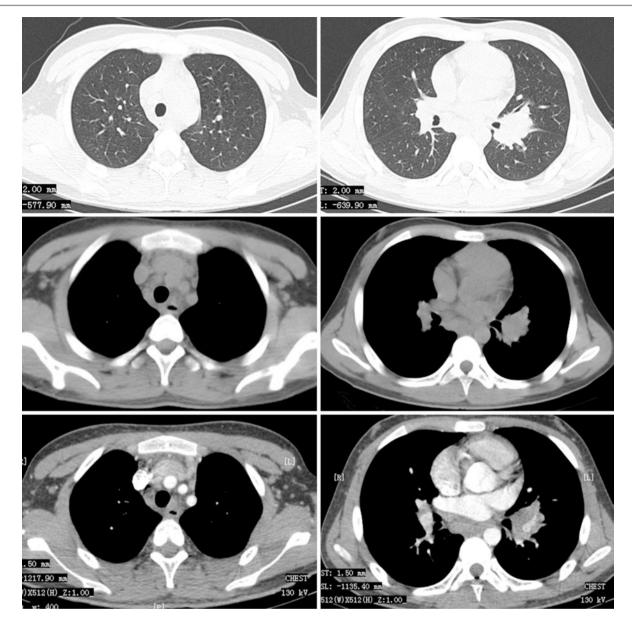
Chest CT images of a 14-year-old man complained of intermittent fever for 20 days
